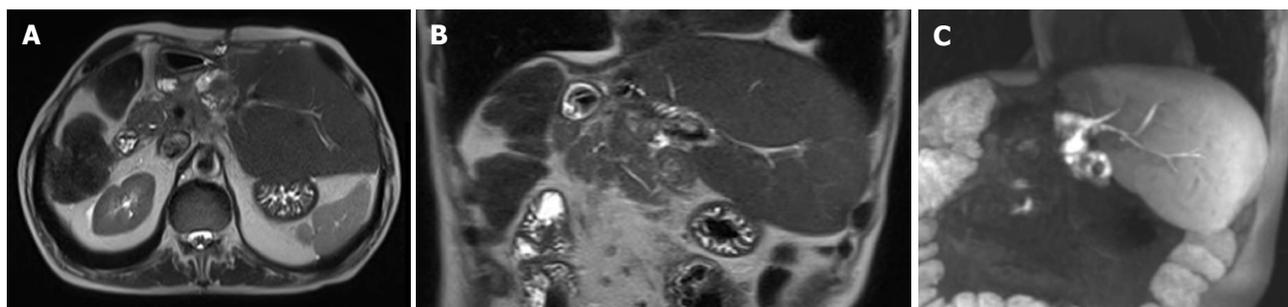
Bilioenteric anastomosis between the jejunum and biliary branches for hepatic segments 2-3 after right trisectionectomy associating liver partition and portal vein ligation for staged hepatectomy performed for hilar colangiocarcinoma showing. A, B: Magnetic resonance imaging single-shot turbo spin echo T2 weighted images acquired on transverse (A) and coronal planes (B) show absence of biliary dilatation; C: This finding was confirmed on thick maximum intensity projection coronally-reformatted image acquired on the hepatobiliary phase after gadoteric acid administration, demonstrating regular flow of hyperintense bile.
